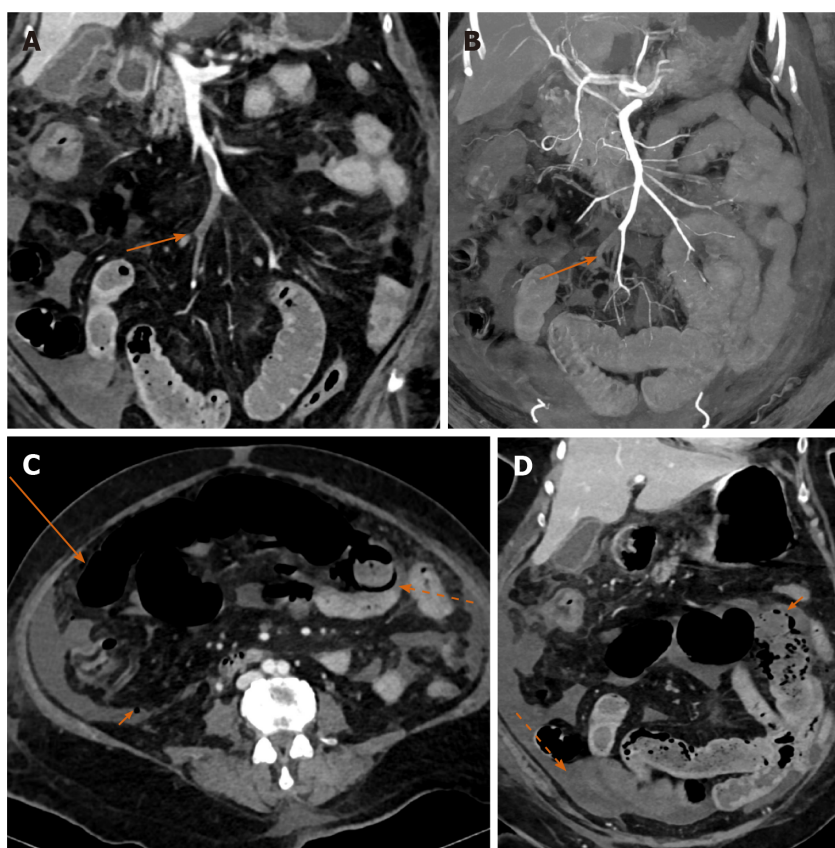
A 65-year-old female with acute mesenteric ischemia. A: Coronal reformatted image of contrast-enhanced computed tomography (CECT) abdomen shows filling defects (orange arrow) in ileal branches of superior mesenteric artery suggestive of thrombosis; B: Coronal reformatted image of CECT abdomen shows occlusion of accompanying tributaries of superior mesenteric vein (SMV) with superior extension of thrombus into the main stem of SMV; C: Axial CECT image showing dilated small bowel with paper thin wall (long orange arrow), circumferential pneumatosis (dotted orange arrow) and foci of free extraluminal air (small orange arrow) indicating transmural bowel necrosis with perforation; D: Coronal CECT image showing a bowel segment with absent mural enhancement (solid orange arrow), and ascites (dotted arrow).
